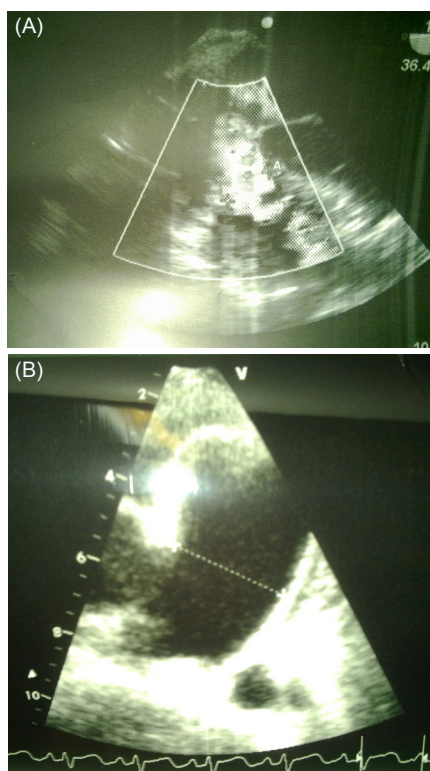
Patient's echocardiography showing VSD with Doppler (A) and without Doppler (B).
